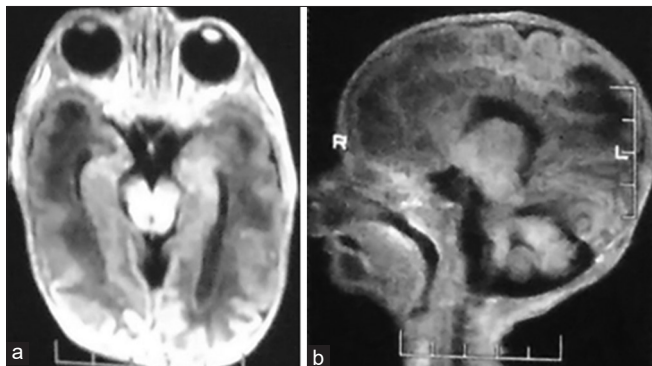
(a) T1 axial MRI brain revealing ill-defined areas of altered signal intensity involving subcortical white matter in bilateral parafalcine parietal lobes, temporal lobes. (b) T1 sagittal MRI brain showing ill-defined hypointense areas of altered signal intensity over anterior frontal lobes
